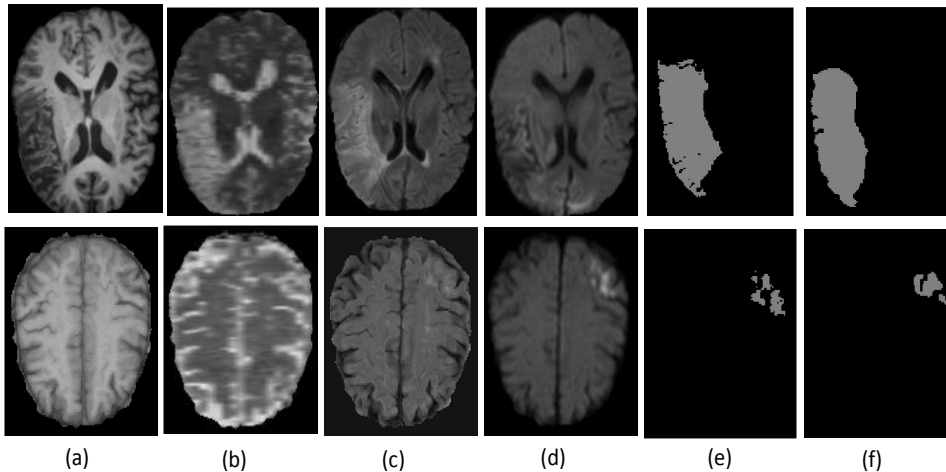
Segmented lesions with corresponding input and ground-truth images. Each row represents an example set of multimodality MRI slices; Input: (a) T1, (b) T2, (c) Flair (d) DWI (e) Segmented lesion (f) ground-truth.
